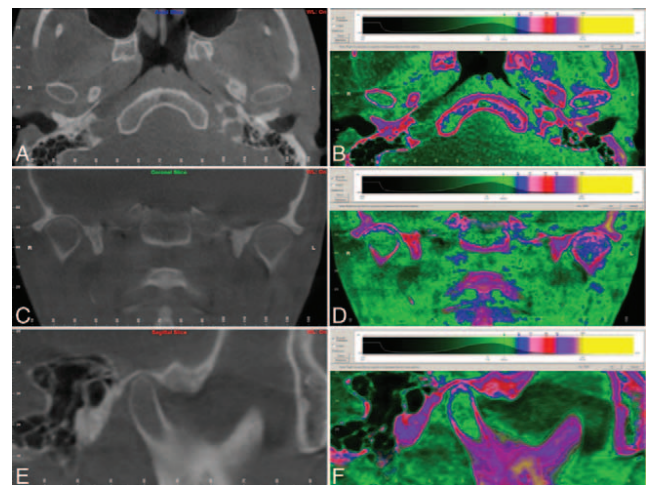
Case 2, CBCT. A. Axial view of condyles. B. Axial view of condyles with Hounsfield scale. C. Coronal view of condyles. D. Coronal view of condyles with Hounsfield scale. E. Sagittal view of condyles. F. Sagittal view of condyles with Hounsfield scale. CBCT, cone beam computed tomography.
